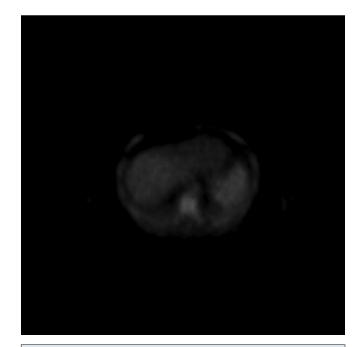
PET-CT showing diffuse uptake in a moderately enlarged spleen; moderate hypermetabolism in all vertebral bodies. He was injected with 296 MBq (8 mCi) F-18 FDG.
